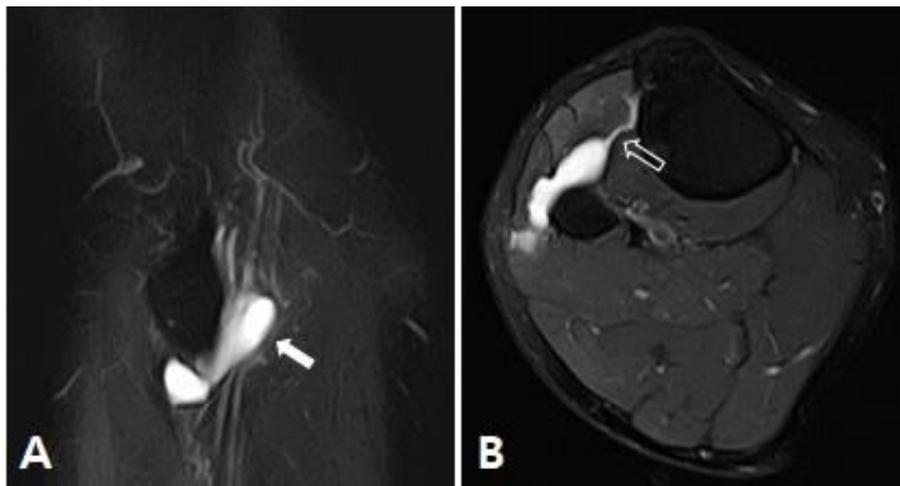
Magnetic resonance image (MRI) of right knee shows findings of intraneural ganglion cyst. (A) Sagittal and (B) axial scans of MRI demonstrated cystic articular branch with balloon-like expansion at the level of the common peroneal nerve and multi-lobulated cystic lesion with high signal intensity around the fibular neck.
